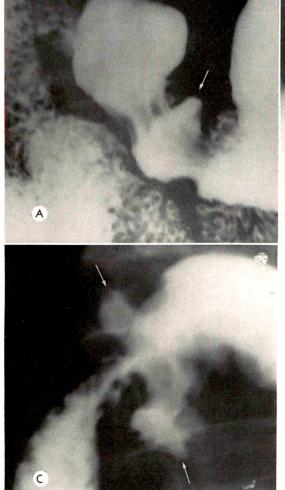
Roentgenograms made with compression at the time of fluoroscopy. (A) This patient demonstrates projection of barium above the gastric contour. (B) The deformity projects below the gastric contour. This appearance is the one most often encountered. (C) A combination of protrusion above and below the gastric contours. Note the demonstration of normal gastric mucosal pattern in the base of the inferior pouch.
